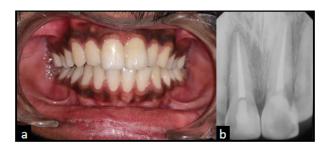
1 year follow-up; a: Clinical view; b: Radiograph (no evidence of root resorption/ankylosis)
